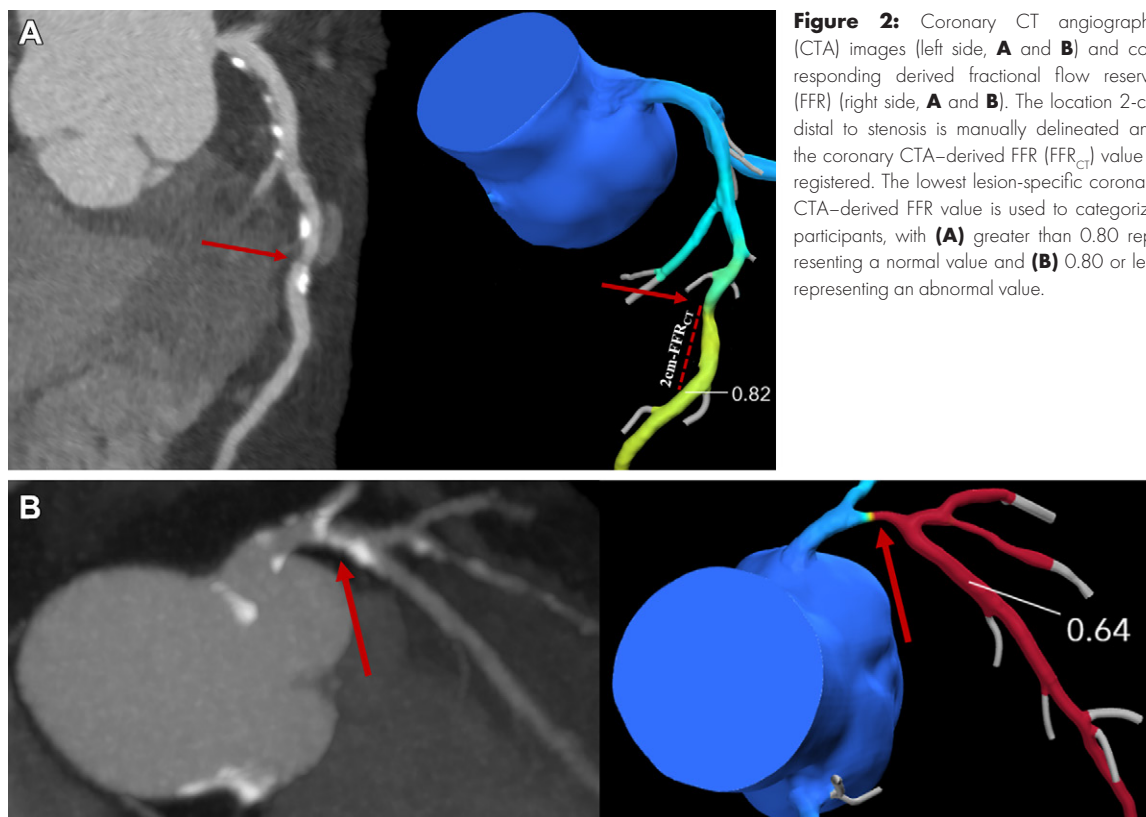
Coronary CT angiography (CTA) images (left side, A and B) and corresponding derived fractional flow reserve (FFR) (right side, A and B). The location 2-cm distal to stenosis is manually delineated and the coronary CTA-derived FFR (FFR_{CT}) value is registered. The lowest lesion-specific coronary CTA-derived FFR value is used to categorize participants, with (A) greater than 0.80 representing a normal value and (B) 0.80 or less representing an abnormal value.
